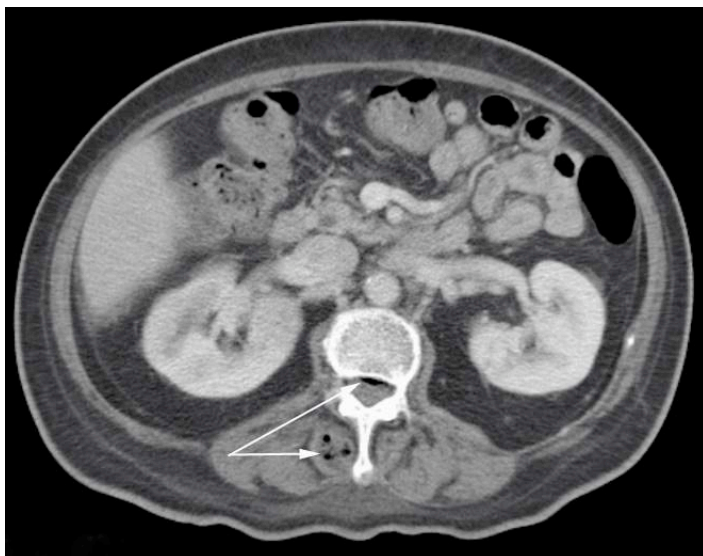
The air in the right paraspinal musculature and spinal column seen on the computed tomography are the first evidence of the lumbar spinal epidural abscess.
